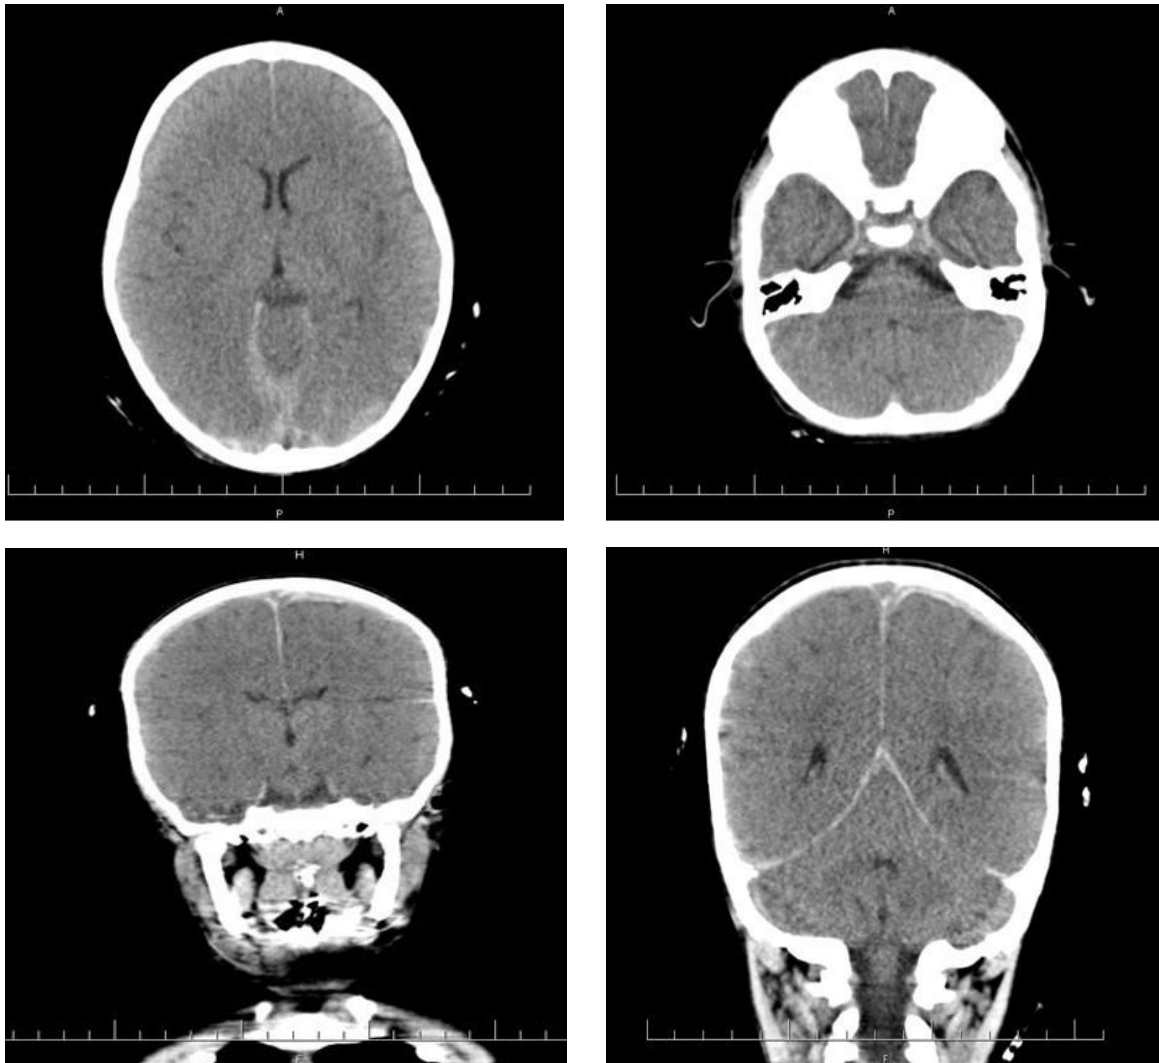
CT finding in a three-year-old child.
